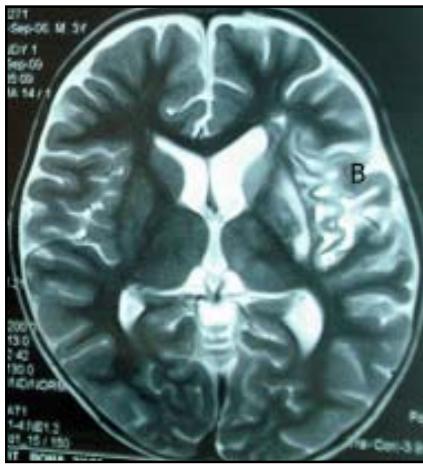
MRI showing acute cerebral infarct involving the left MCA territory (B).
